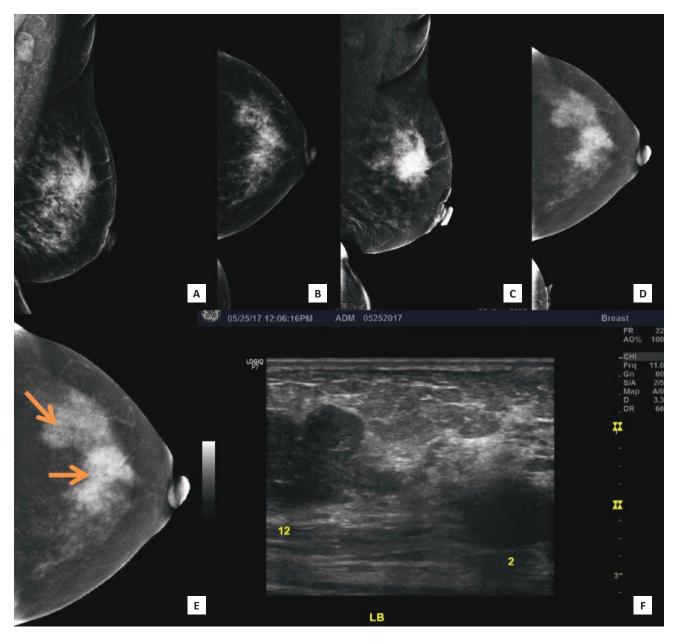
A 56-year-old premenopausal female presenting with a palpable left breast mass, Family history revealed she had two (2) sisters who had breast cancer in their 50's. (A, B) LE MLO and CC views of the left breast showing heterogeneously dense breast composition. There is an irregular mass of increased density at the mid upper quadrant and a second equal density mass with partly obscured margins at the upper outer quadrant (C, D) Subtracted images (SI) in MLO and CC projections show an enhancing irregular mass at the mid upper left breast and shows the second enhancing mass with lobulations at the upper outer quadrant on a background of moderate parenchymal enhancement. (E, F) SI Image of the left CC view and the correlate ultrasound image showing multifocal breast lesions at the 12 o'clock (orange arrow) and 2 o'clock (orange arrowhead) positions.
